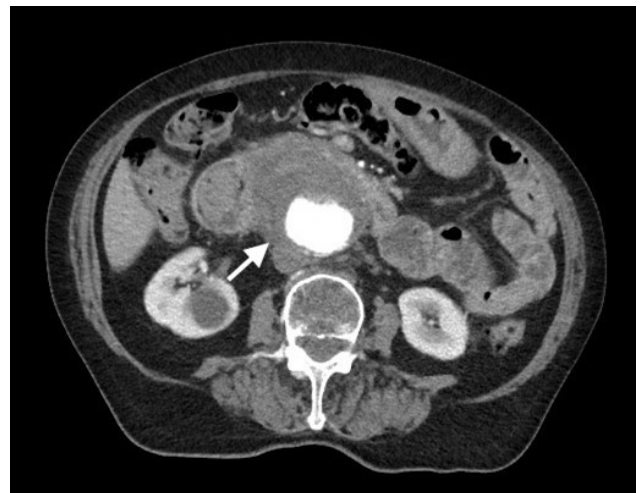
CT scan during hematemesis. The white arrow points the infrarenal aortic aneurysm.
